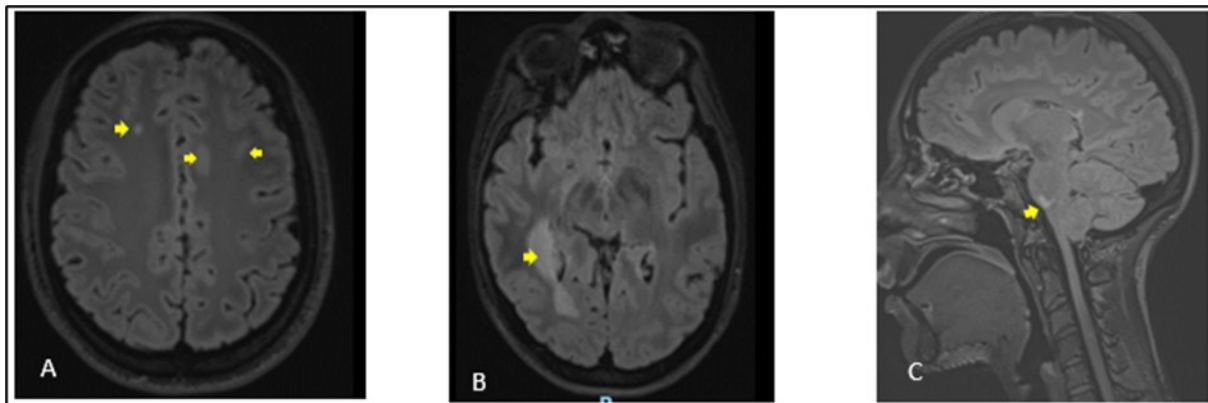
Cerebral MRI in FLAIR sequences showing multiple hyperintense lesions at the supratentorial (A, B) and infratentorial (C) levels. The largest supratentorial lesion (B) is opposite the right paraventricular white matter, at the level of the posterior horn and measures 55 x 17 mm axially. Presence of a lesion of pons (C) of 6.5 mm.
